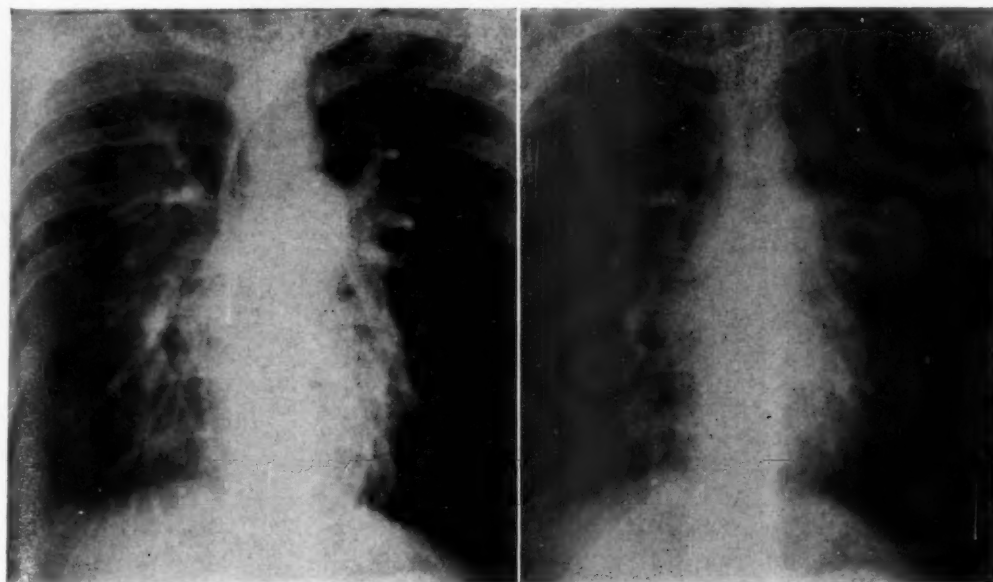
Posteroanterior roentgenogram of the chest. Arrows identify the abnormal right juxtacardiac shadow which was demonstrated to be an anomalous right pulmonary vein. There is evidence of right-sided enlargement associated with a prominent pulmonary artery and increased pulmonary vascular markings.
